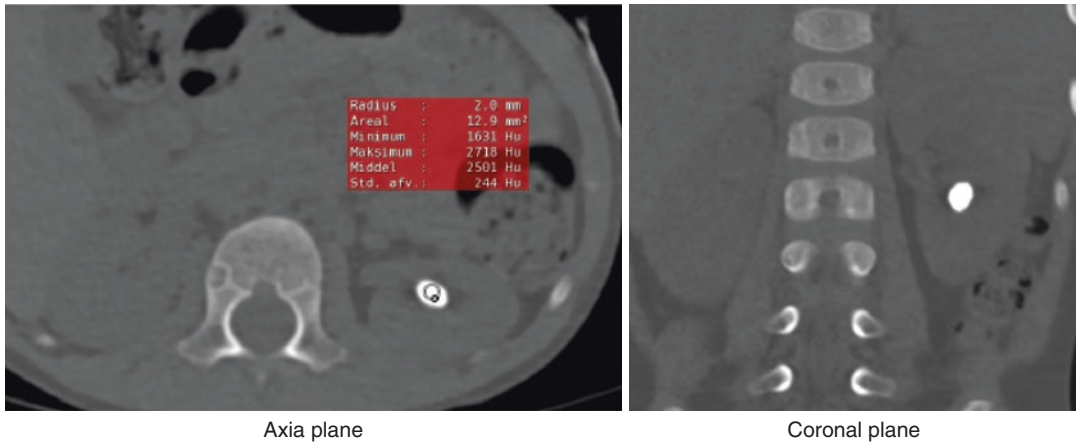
Ultralow dose computerized tomography [ULD-CT]. (ULD-CT in a 3-year-old boy with a very dense stone [mean HU 2501]. The examination could be designed with a radiation dose of 0.36 mSv, which is comparable or even less than a KUB. The boy was treated by
